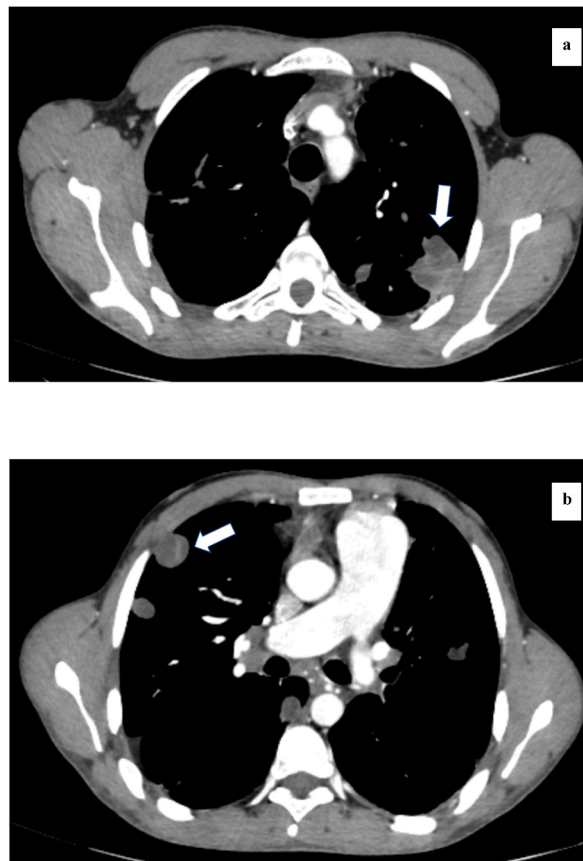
(a, b). Axial post-contrast CT scan images: Pulmonary nodules compatible with echinococcal cysts in both lung parenchyma, containing floating membranes (arrow).
